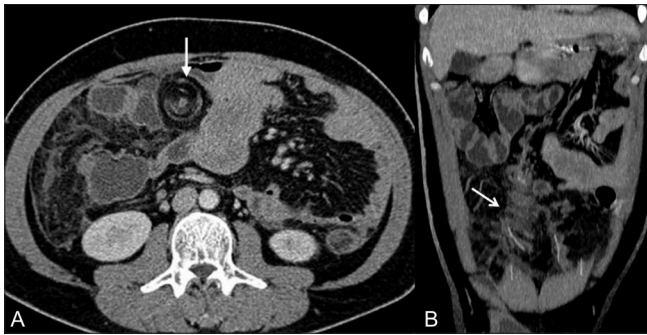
(A, B): Axial (A) and coronal (B) contrast-enhanced CT scans show a hazy fat-density mass in the right side of the abdomen, with concentric linear strands (white arrow) in the greater omentum. These strands represent blood vessels twisted around a central vascular pedicle
